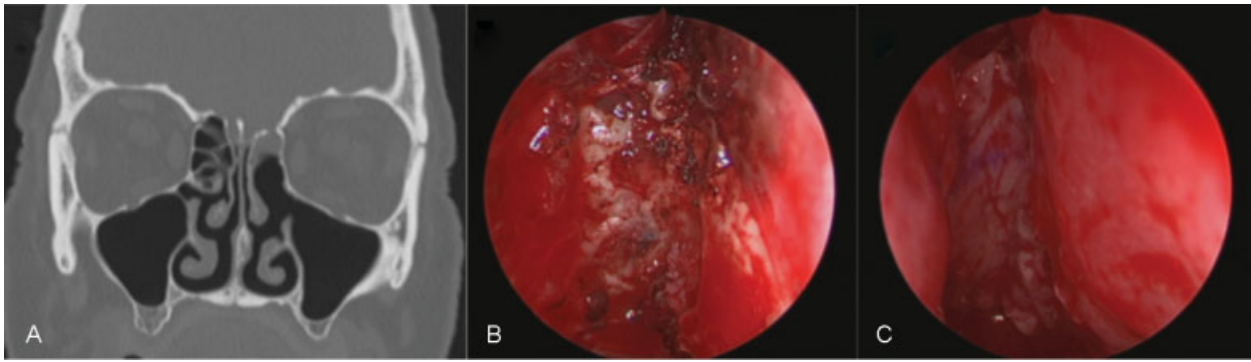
Patient with history of head trauma presenting with left-sided CSF rhinorrhea. (A) Coronal CT scan showing a left ethmoid skull base defect. (B) Intraoperative image of left skull base defect (5 mm). (C) Repair of skull base defect with pedicled nasoseptal flap. CT, computed tomography; CSF, cerebrospinal fluid.
